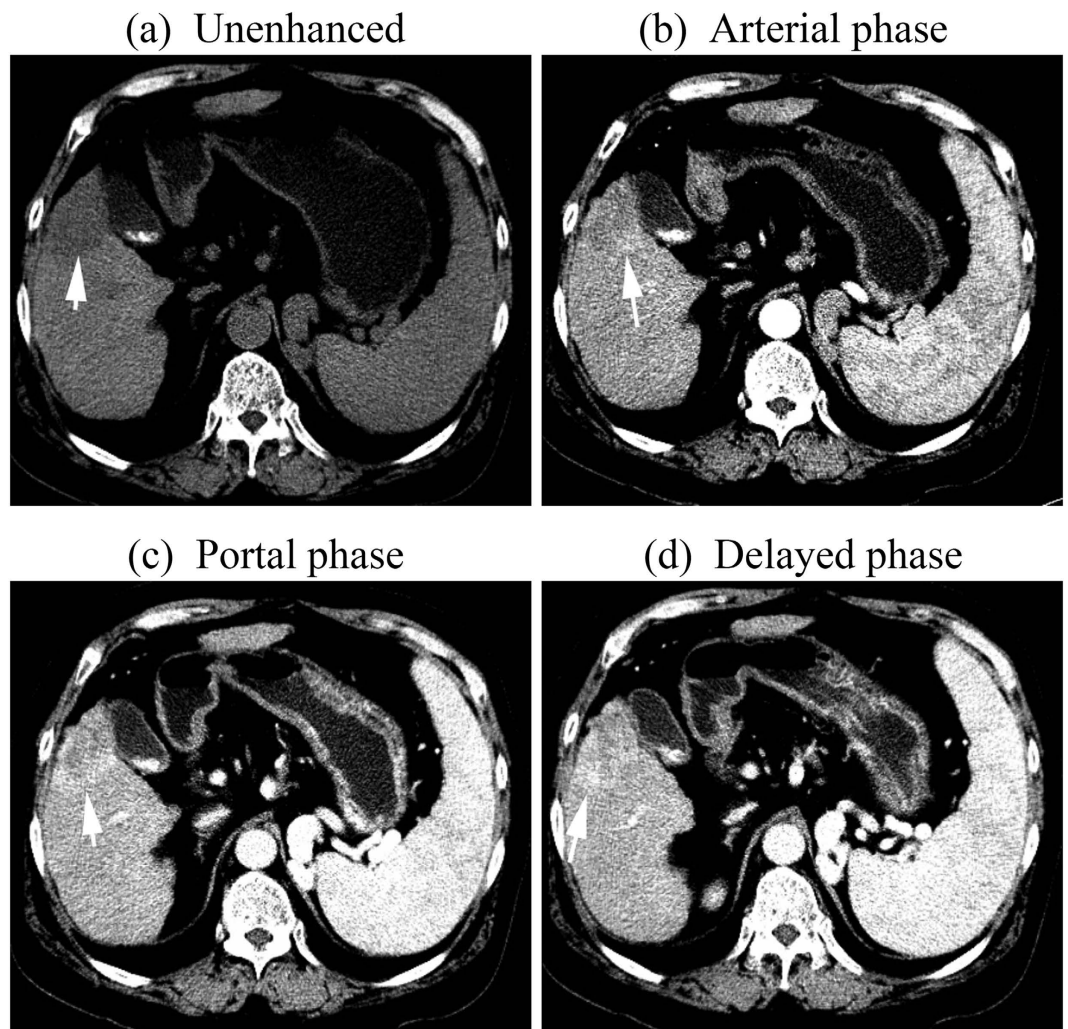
tif CT images of a 75-year-old man with a 3.8-cm -diameter ICC displaying progressive contrast enhancement pattern. (a) unenhanced, (b) Arterial, (c) portal, and (d) delayed phases. After intravenous contrast administration, the nodule shows progressive centripetal enhancement (arrow).
